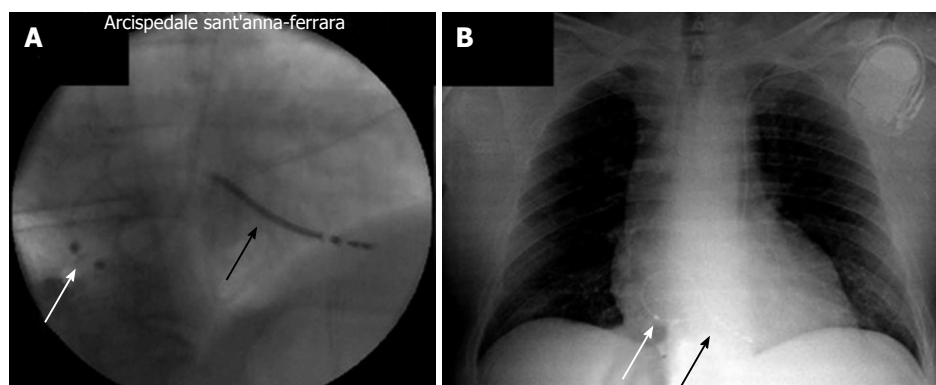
Final position of implantable cardioverter defibrillator sensing dipole. A: Fluoroscopic posteroanterior view during implantation; B: Chest X-ray after implantation. Note the position of atrial sensing dipole (white arrow) and defibrillation coil (black arrow).
